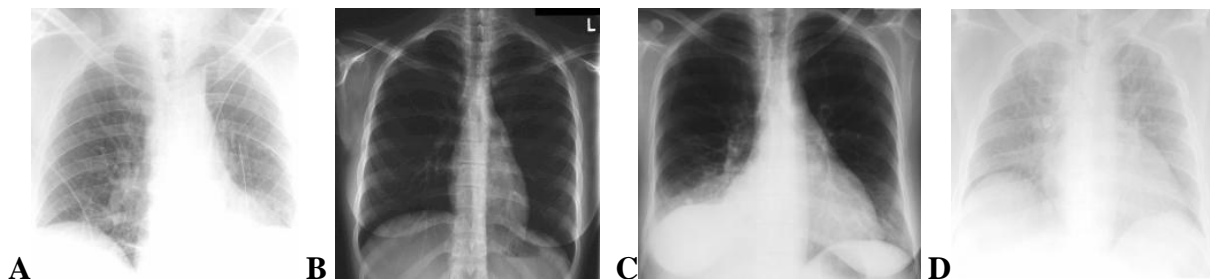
(A) Under-penetrated radiograph. Notice that the overall degree of blackening in the lungs is appropriate (exposure) but there is essentially no detail visible through the heart (indicating poor penetration). (B) Over-penetrated radiograph. Notice how unusually well the vertebral bodies are seen through the heart. The problem with over-penetration is evident in the lung fields, where detail of the parenchymal process is lost because of the poor technique. (C) Over-exposed radiograph. Notice that the lung fields appear far too black and almost all detail is lost, though the penetration is correct (the vertebral bodies are just discernable through the heart). (D) Under-exposed radiograph. Soft tissues in the image appear too white. The problem is clearly one of exposure, though, because the vertebral bodies are discernable through the heart
